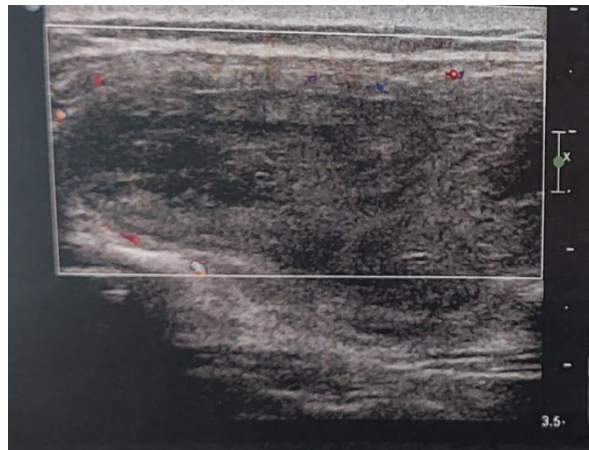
Thoracic ultrasound revealed a heterogeneous parietal collection.
